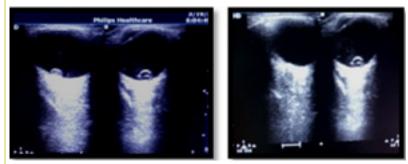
Ultrasound examination showing bilateral crystalline lens dislocation into the vitreous cavity
